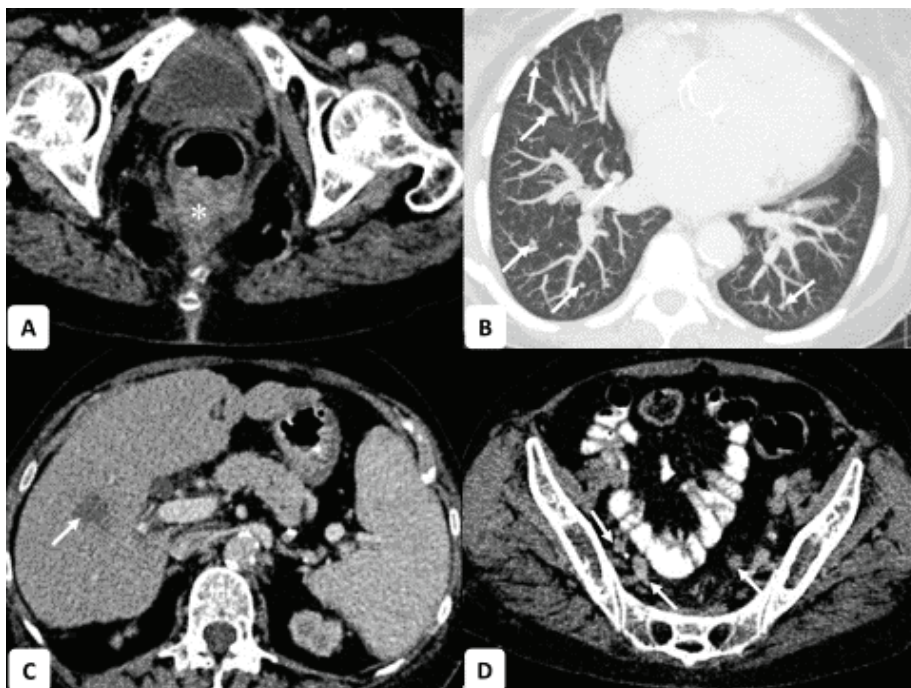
CT-scan of thorax/abdomen/pelvis in axial cut showing heterogenous enhancing irregular bowel wall thickening involving the anorectum (asterix in image A). Images B, C and D revealed multiple lung (white arrow in image B), liver (white arrows in image C) and nodal (white arrow in image D) metastases.
